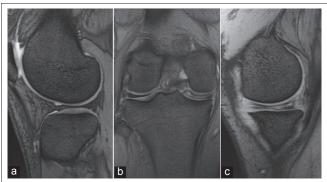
T2-weighted coronal and sagittal magnetic resonance imaging (MRI) of his right knee. (a) T2-weighted sagittal MRI at lateral side. It showed lateral meniscus had no tear, (b) T2-weighted coronal MRI. It revealed medial and lateral complete discoid meniscus. (c) T2-weighted sagittal MRI at medial side. It showed medial meniscus had a horizontal tear.
